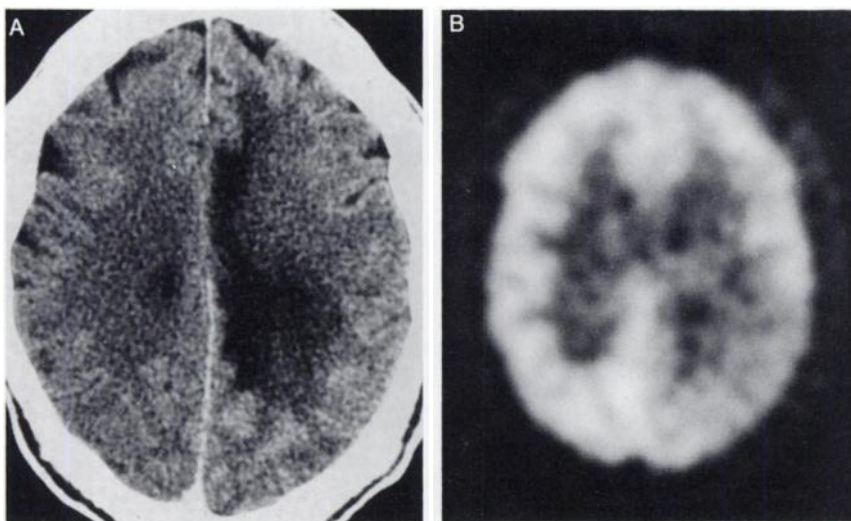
Patient 8 (Table 1). Contrast-enhanced CT scan (A) shows changes localized to the left frontal and parietal white matter. FDG-PET study (B) demonstrated grade 3 inhomogeneous FDG uptake in the left parietal white matter. This individual had presumed PML.
